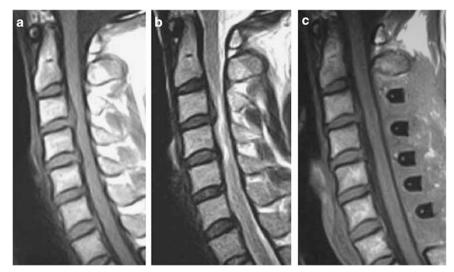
Surgical treatment case. (a, T1—weighted image) Cervical spinal cord compressed by a disc. Compression rate was 50%. (b, T2-weighted image) High intensity area at C3/4. (c, after surgery) Good decompression after laminoplasty.
